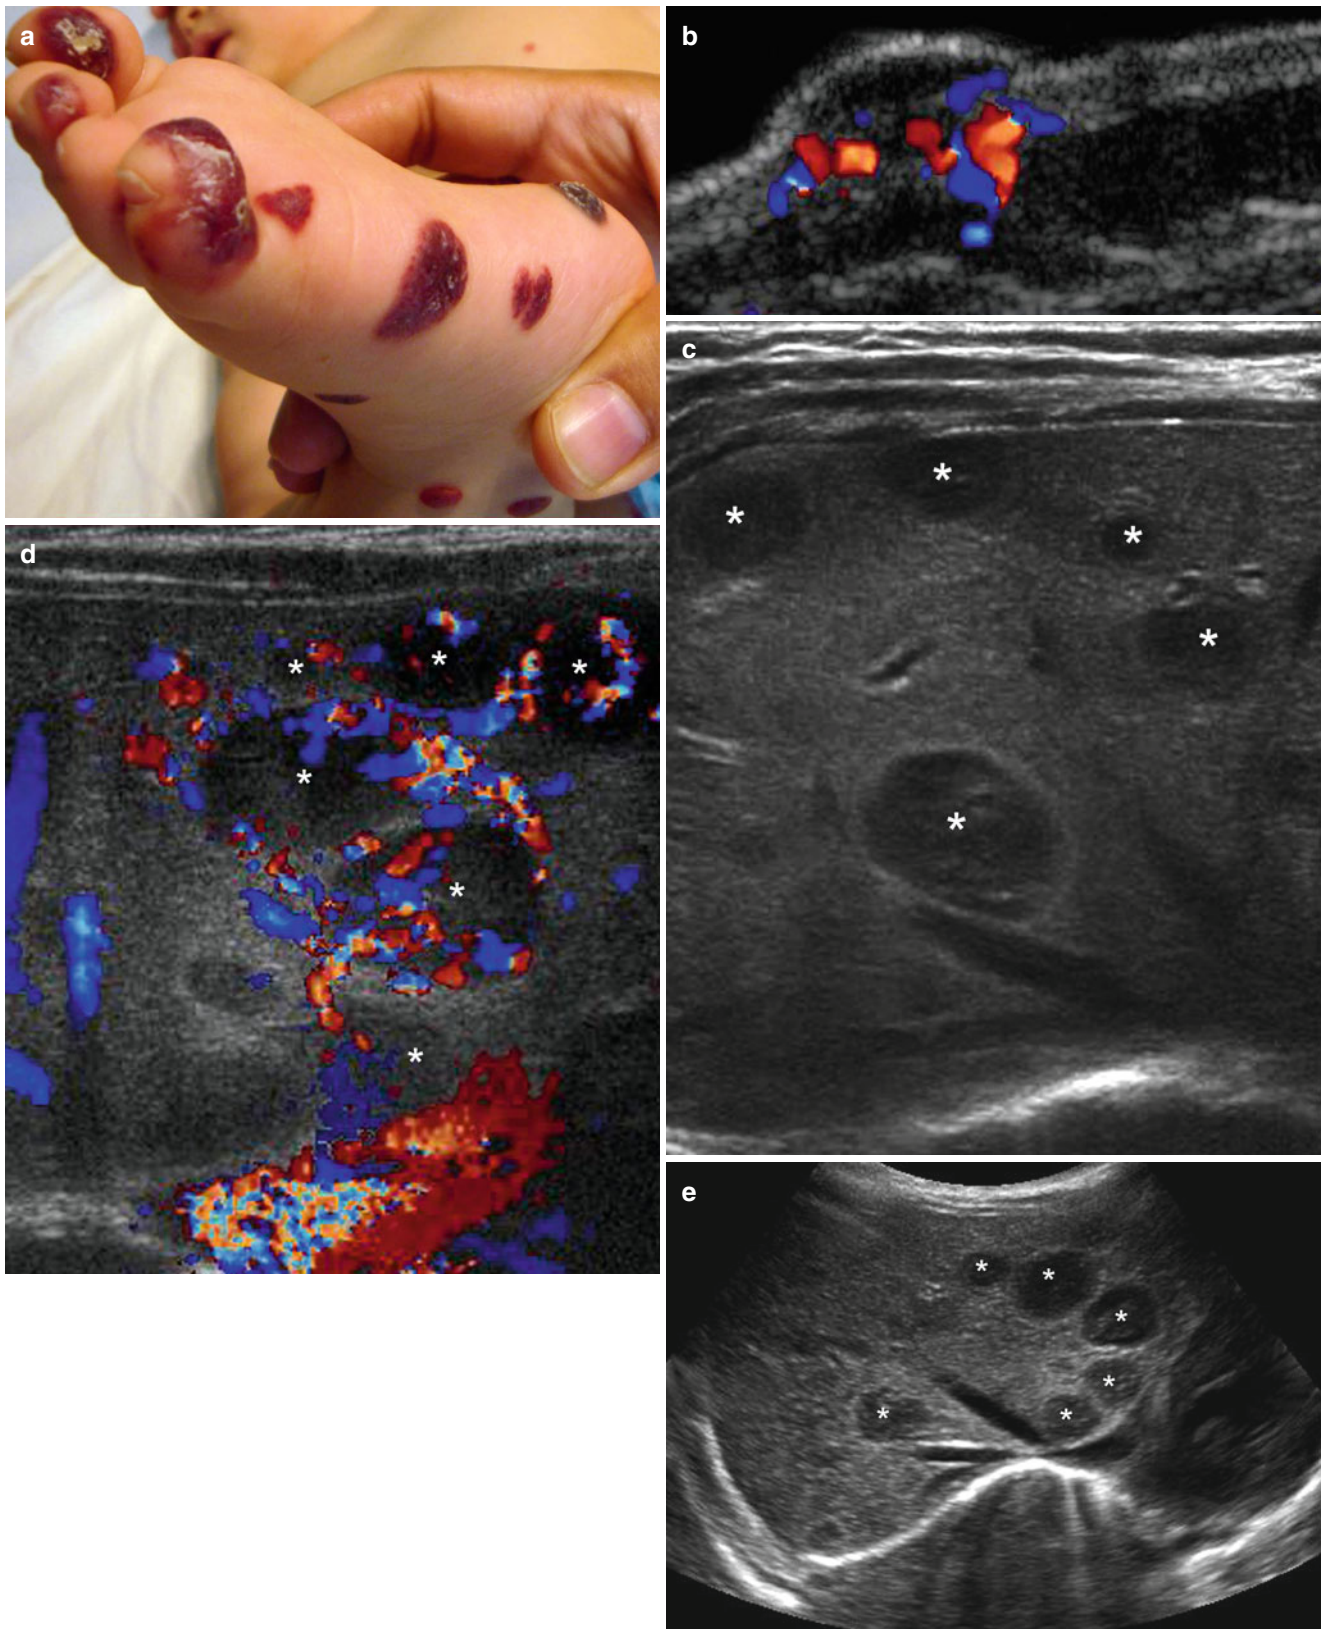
(a–e) Multiple cutaneous and hepatic hemangiomas (proliferative phase). (a) Clinical image shows multiple cutaneous hemangiomas in the right foot. (b) Grey scale ultrasound image (transverse view) of one of the lesions demonstrates hypoechoic mass affecting dermis and subcutaneous tissue with increased blood flow. (c) Grey scale ultrasound image of the liver (transverse view) in the same patient
